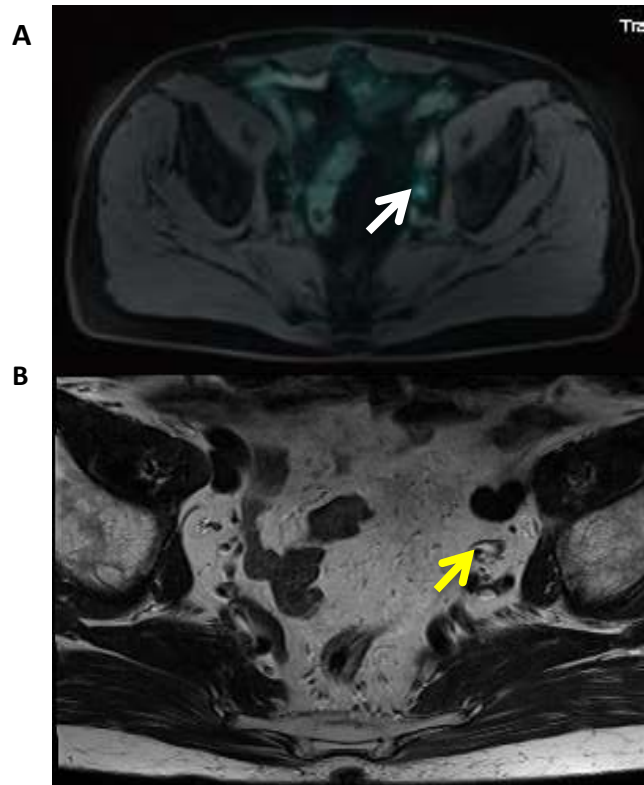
PSMA PET/MRI imaging for BCR002 demonstrating an isolated PSMA avid right external iliac lymph node (white arrow)
